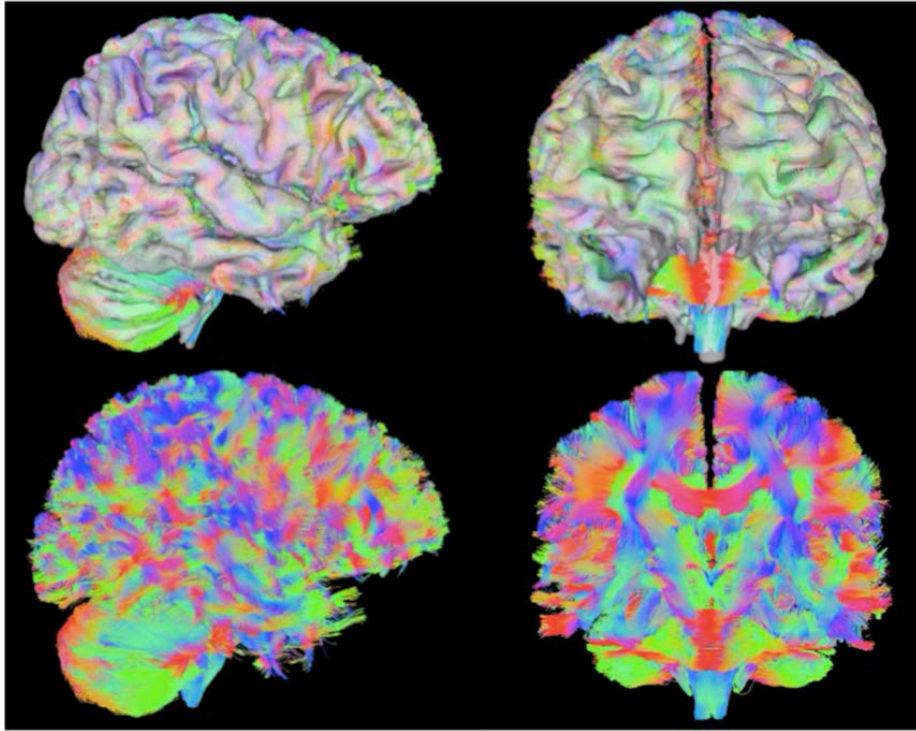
Using Deterministic tractography to estimate white matter streamlines from diffusion MRI data.
